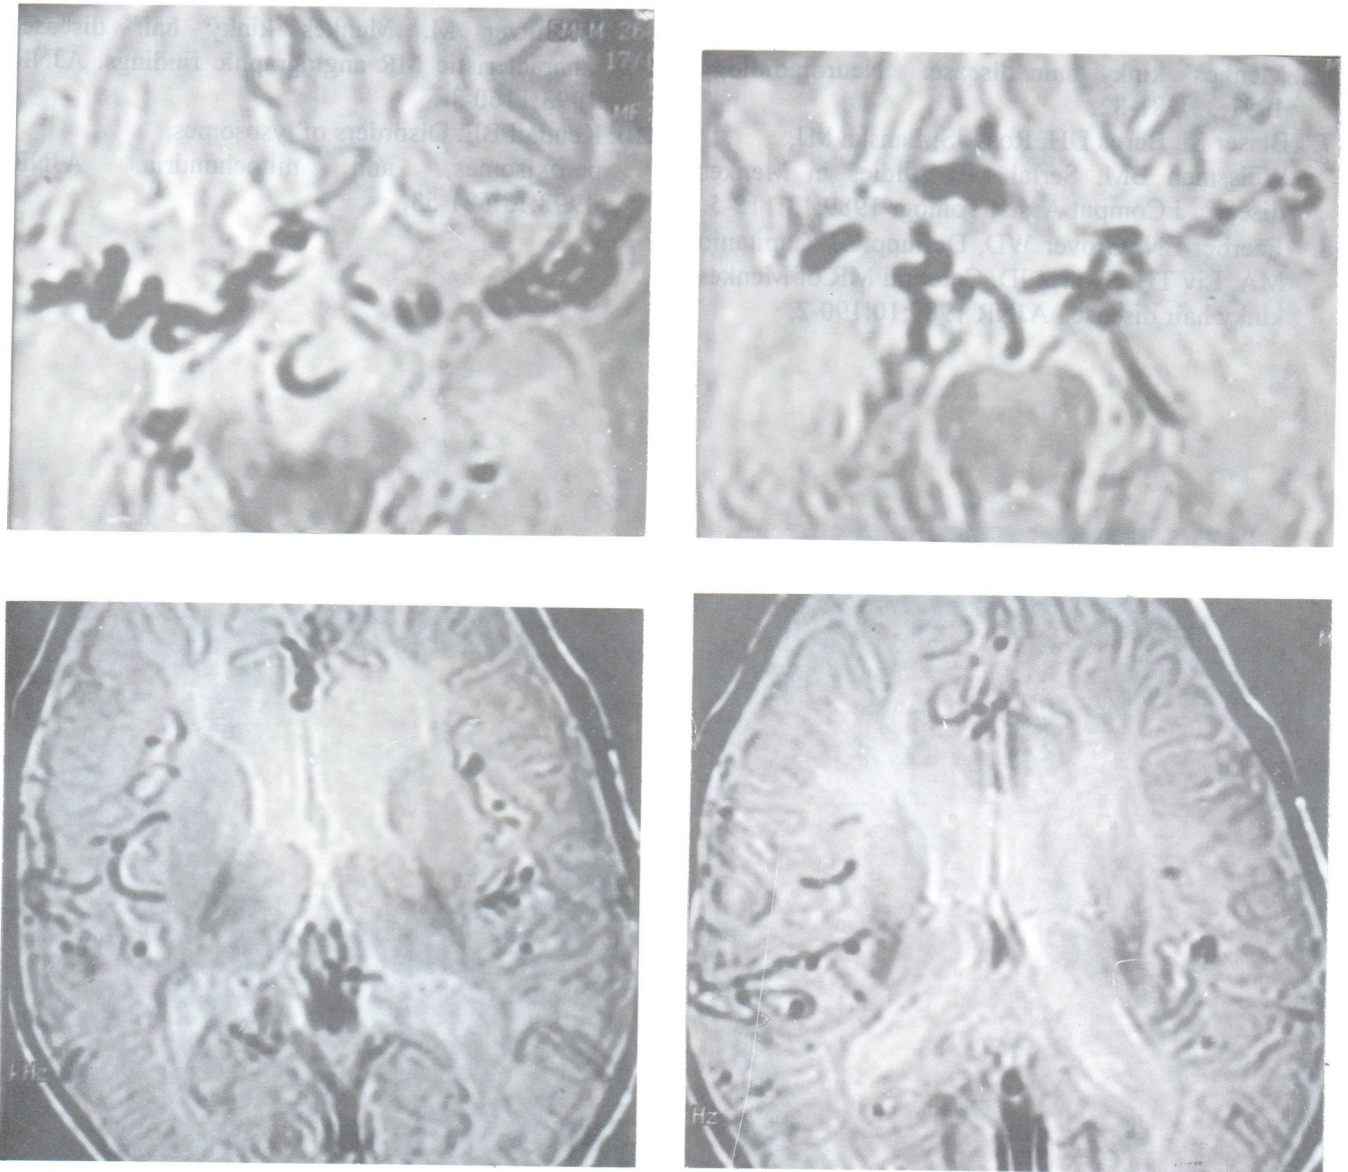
PD axial MRI images of the brain shows kinking and tortuosity of the intracranial arteries.
